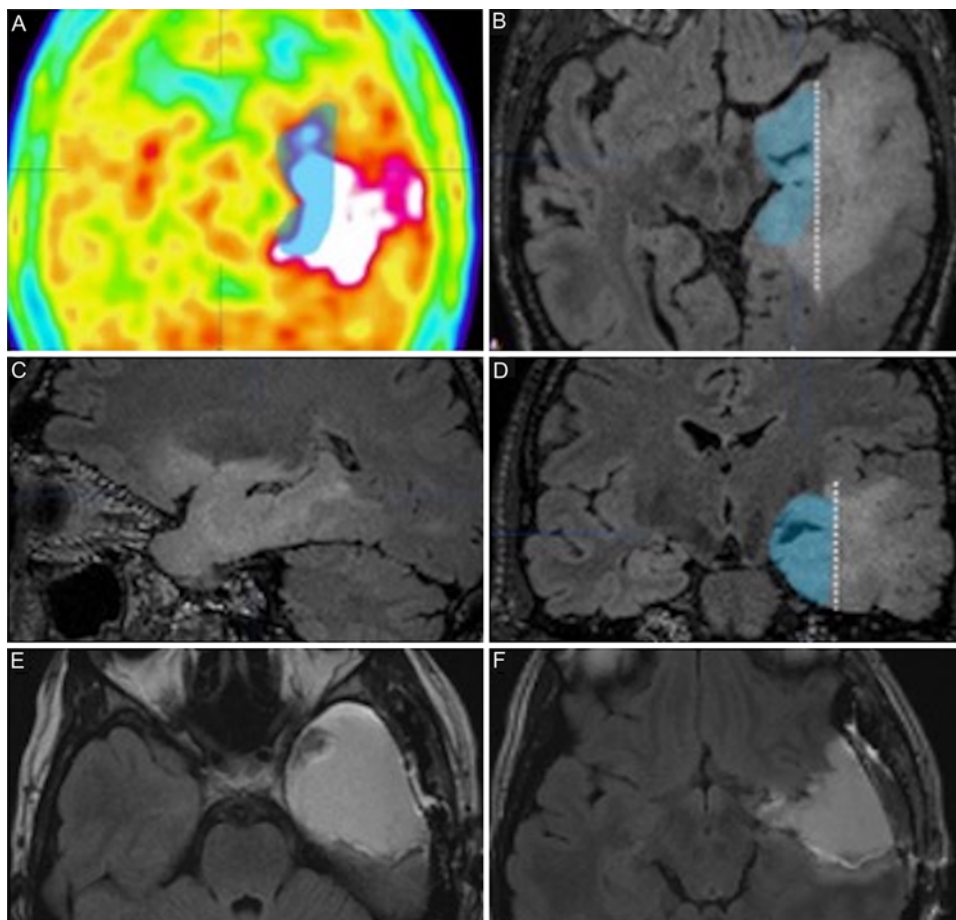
A–D: Preoperative PET-MRI FLAIR sequences obtained in a 27-year-old woman with a left IDH-mutant grade 2 astrocytoma and uncontrolled seizures at surgery (sudden feeling of anxiety and fear, déjà vu, visual hallucinations) despite triple AED treatment. Axial MET PET scan showing high radiotracer uptake within the left TMa (A). MRI FLAIR sequences with axial (B), sagittal (C), and coronal (D) images showing the tumor. The TMa is delimited laterally by a line passing just medial to the collateral sulcus (*white dotted line*), including the amygdala and the hippocampus (head and first portion of the body). PET-MRI TMa overlap is highlighted in *light blue* (panels A, B, and D). E and F: Postoperative axial MRI FLAIR sequences obtained in the same patient, showing the complete resection of the tumor. The patient experienced no postoperative deficit except a transient superolateral visual field impairment, and she was completely seizure free 1 year after surgery (Engel class I).
